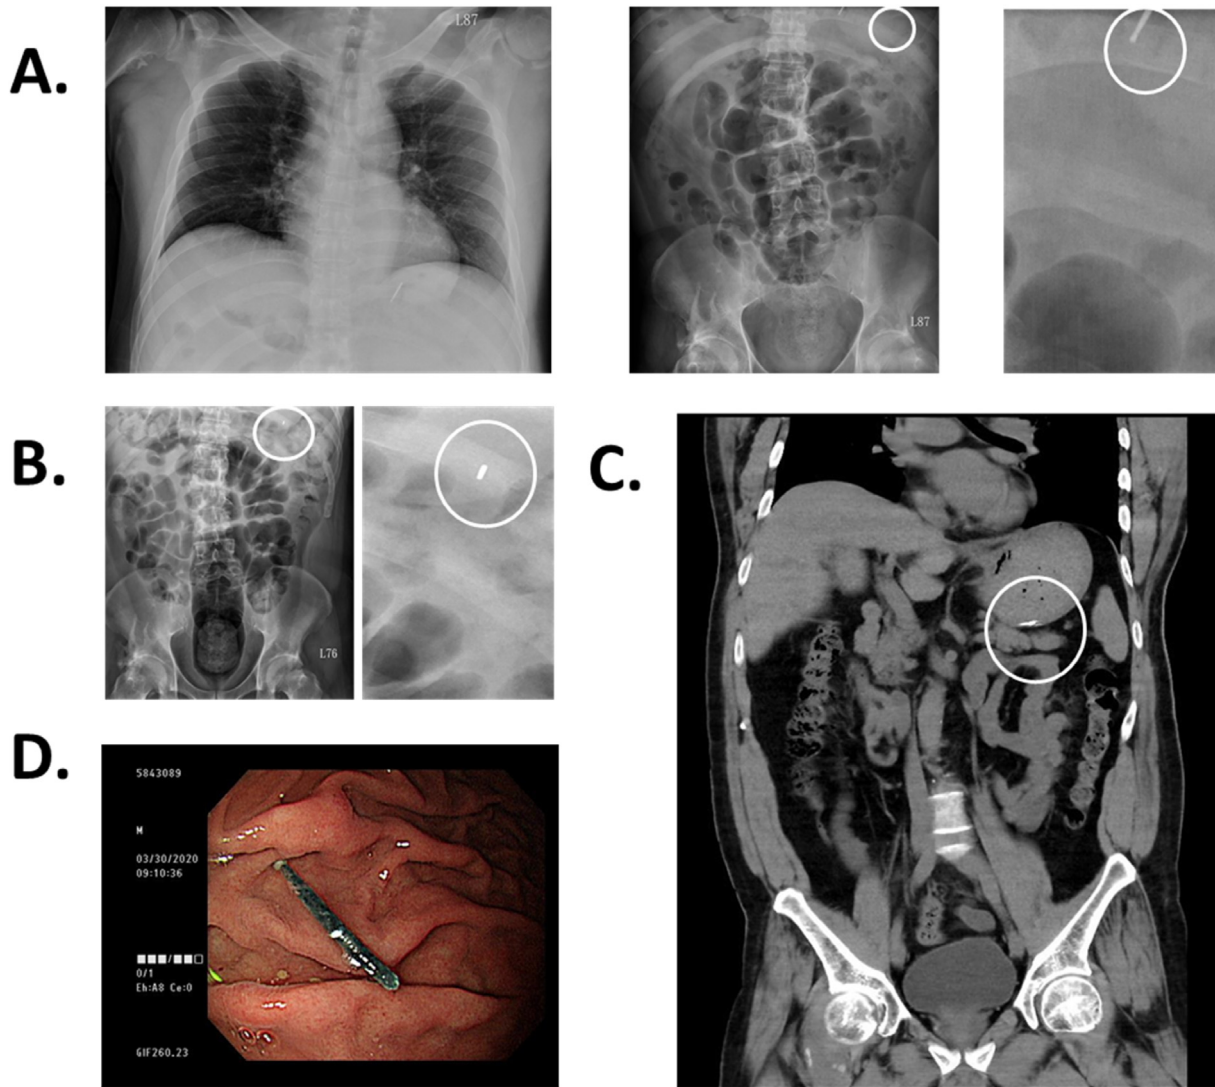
In Case 9, a high-speed diamond round bur was accidentally ingested during a dental procedure. A. The chest and abdominal radiographs taken on the same day revealed the bur in the stomach area. B. One week later, the follow-up radiograph showed the bur remained in a similar position without the significant movement. C. Computed tomography confirmed the location of the bur in the lower portion of the stomach body. D. During the panendoscopy examination, the bur was found resting on the stomach mucosa and was successfully removed 12 days after the accidental ingestion.
